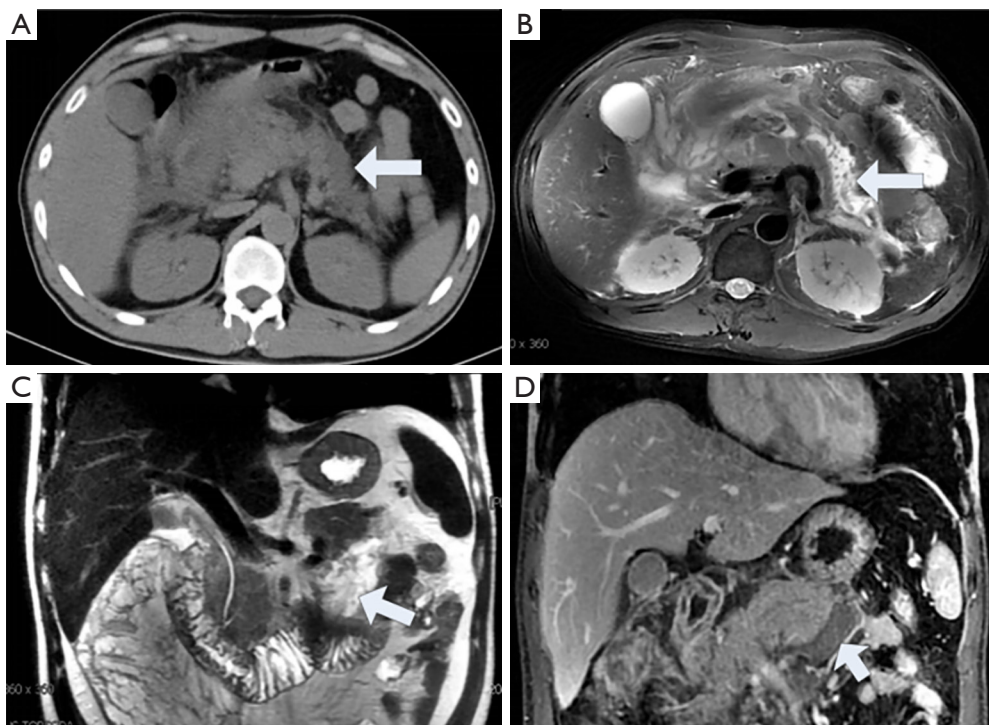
A 39-year-old female with peripancreatic necrosis underwent CT and MRI within 7–10 days after onset. On plain CT scans (A), the peripancreatic collections are uniform (arrows), indicating acute peripancreatic fluid collections. However, on the MRI fs-T2WI (B) and COR-T2WI (C), there are shadows within the patchy hypointense areas of the collections around the body and tail of the pancreas (arrow), and these areas show no enhancement after an administration of contrast agent (D, arrow), indicating acute peripancreatic fluid collections. MRI, MR imaging.
